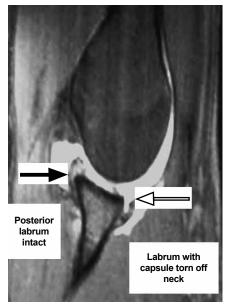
MRI showing Bankart lesion.
